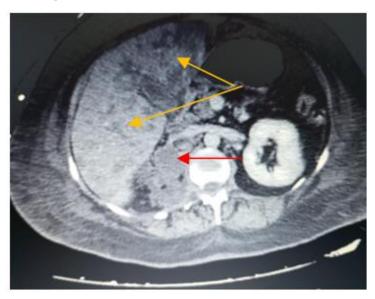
Uro CT scan: Enlarged necrotic portocaval lymph node cluster (red arrow). Multiple hypodense liver lesions (yellow arrow) consistent with abscessed lesions.
